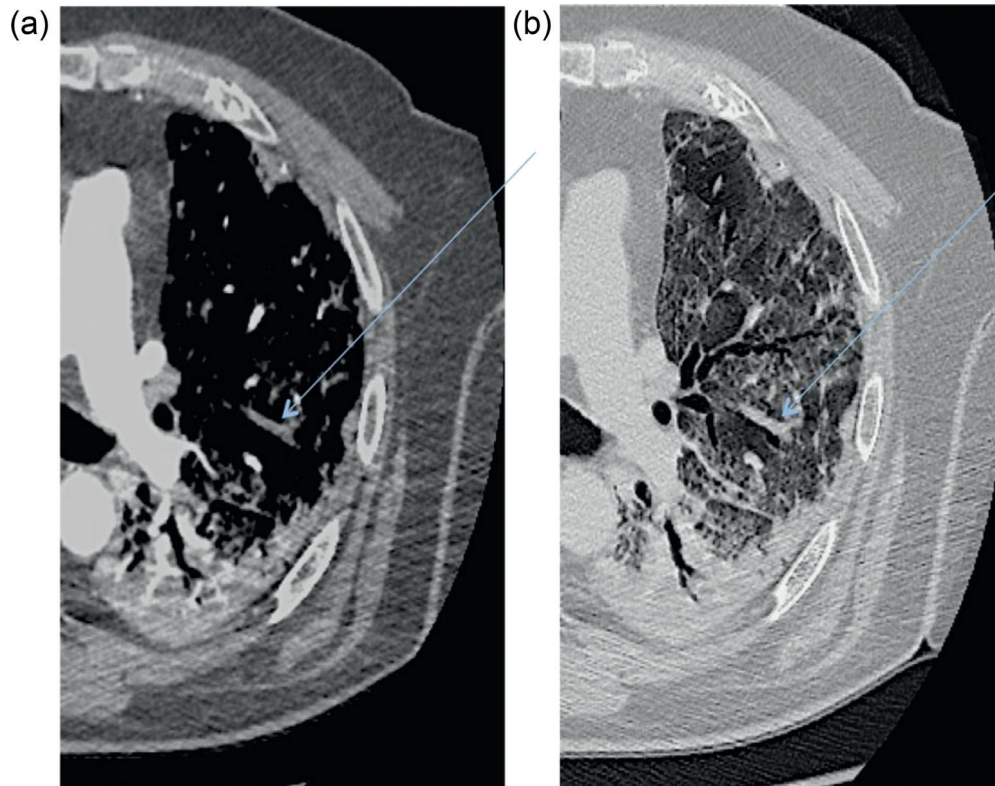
Axial contrast-enhanced CT scan demonstrating a filling defect (A) (blue arrow) in the left upper lobe overlapping the segmental distribution of ground-glass opacities (B). Notably, no filling defects are present in the left lower lobe, where consolidation is the main radiologic pattern of pneumonia.
